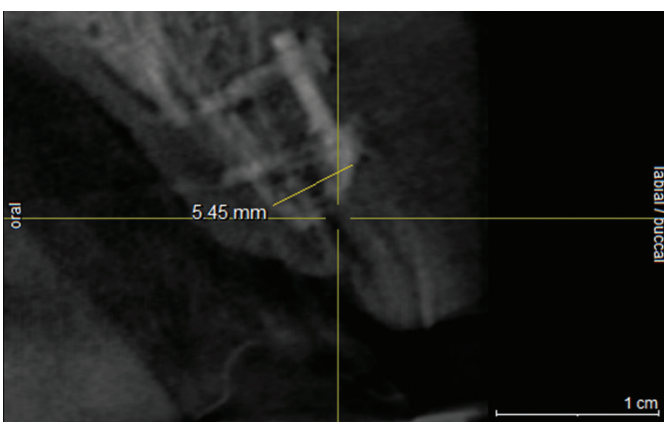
CBCT image showing crestal bone width gain after eight months.
